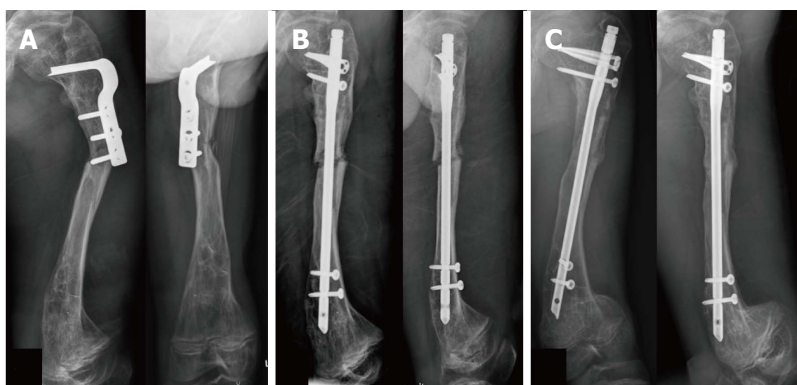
Clinical presentation of case 3 during the first operation. A 16-year-old male with type III osteogenesis imperfecta presented with subtrochanteric peri-implant fracture of left femur after corrective osteotomy and fixation with osteotomy plate for 10 mo. Plain radiographs in anteroposterior and lateral views after injury (A), immediately after humeral nail fixation (B), and 8 mo after humeral nail fixation (C).
